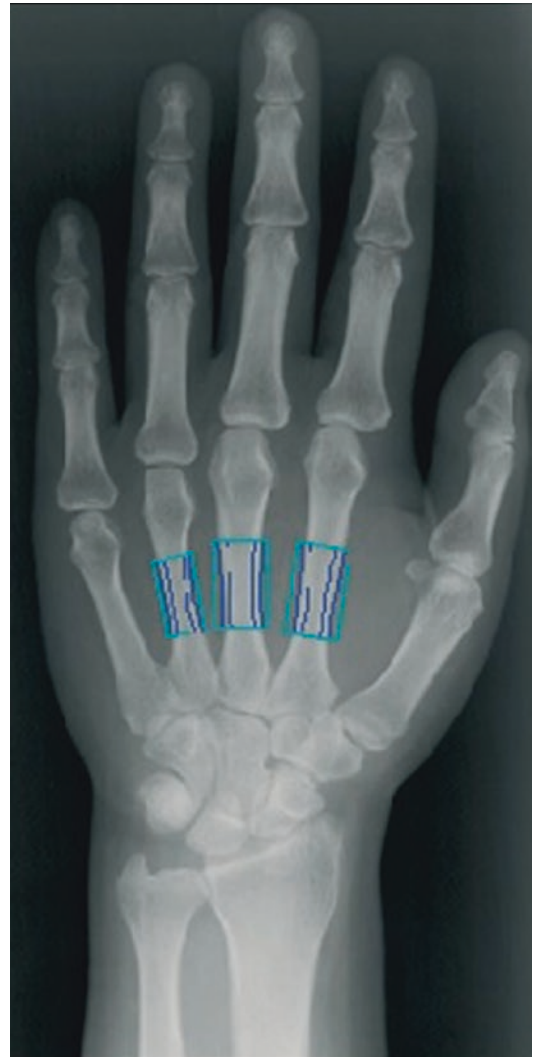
Digital X-ray radiogrammetry. A scanned and processed hand radiograph with the three regions of interests (close up of “B” from Fig. 22.1). The digitized image is subjected to a number of image processing algorithms where the three regions of interests (ROIs) around the narrowest part of the second, third, and fourth metacarpal joints are automatically identified. (Image from Pfeil et al. [30])
